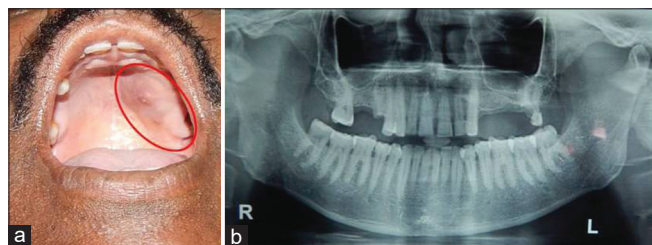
(a) Solitary lesion in the palate, (b) no significant changes seen in the orthopantomograph
